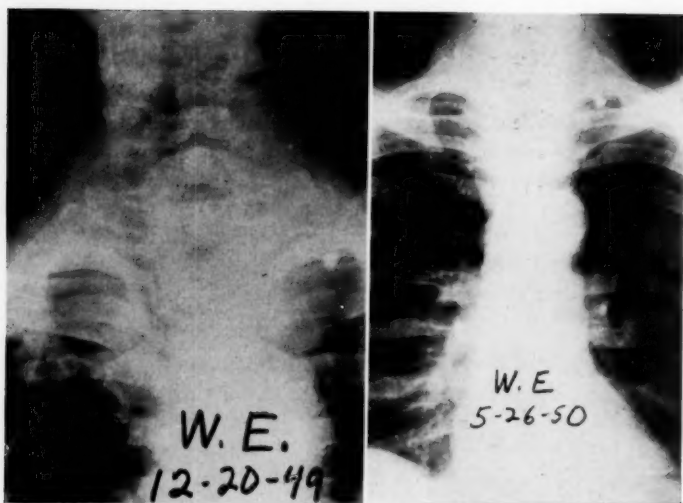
W.E. (Case 1). Note deviation and compression of trachea in preoperative x-ray taken 12-20-49 (left). Subtotal thyroidectomy performed 4-5-50. Postoperative x-ray on 5-26-50 (right) shows return of trachea to midline with less compression.
